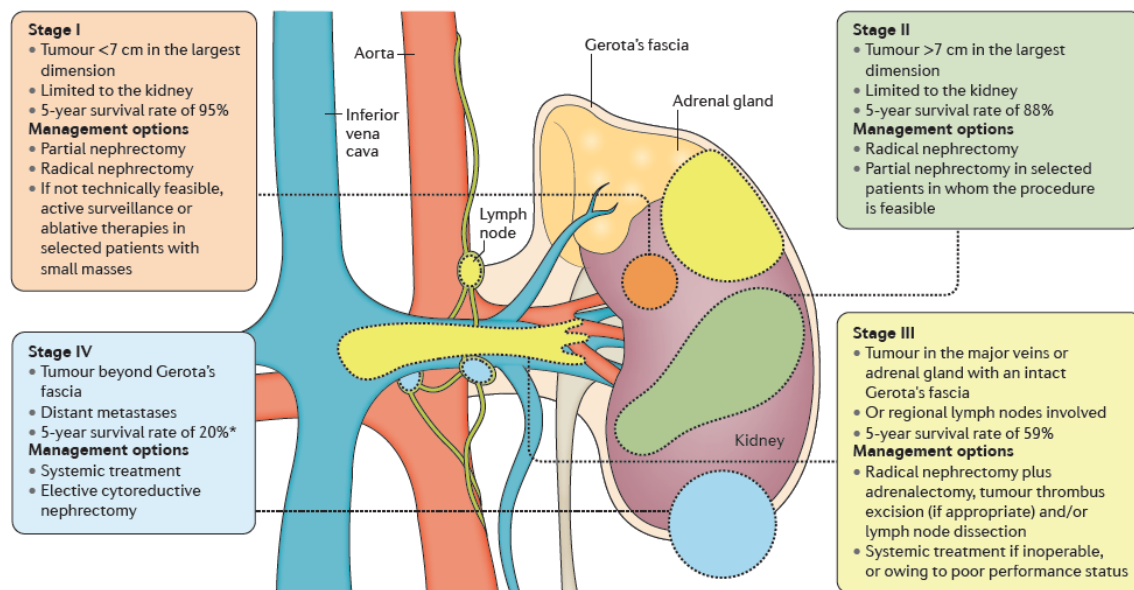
Renal cell carcinoma staging. Tumour staging is mainly accomplished through computed tomography and reflects local invasiveness, lymph node involvement and metastases. Stages I and II are mainly confined to the kidney and surgical procedures remain the main curative treatment for these patients. Stage III reflects tumours enclosed within Gerota's fascia limits. In turn, stage IV RCC reflects distant metastases and treatment options mainly focus on systemic treatments, including Sunitinib, Sorafenib, Bevacizumab and Everolimus. From Hsieh et al. *Nat. Rev. Dis. Primers* 2017³.
